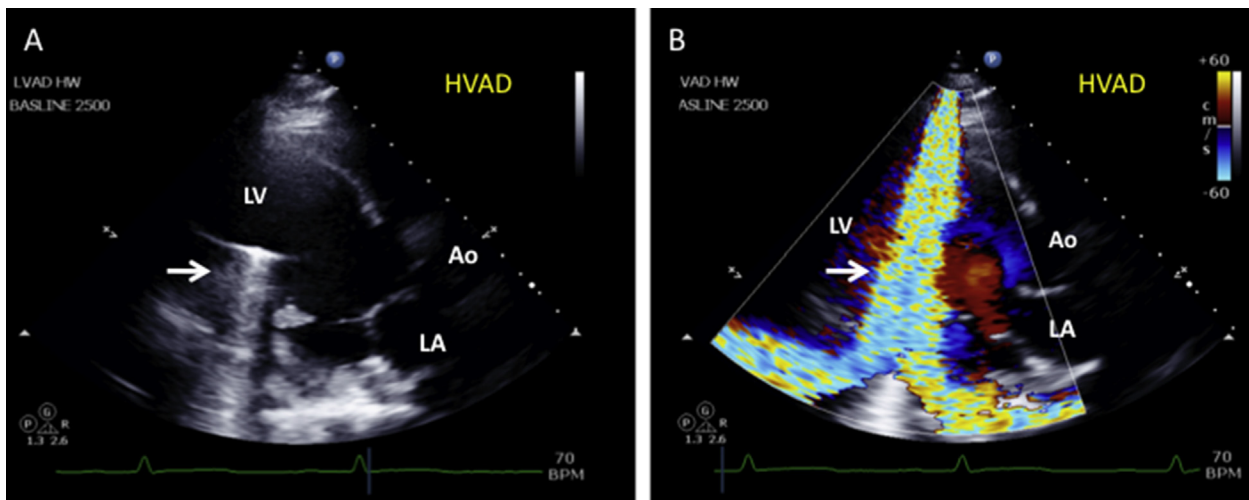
(A) HVAD inflow-cannula artifact (arrow), 2D parasternal long-axis view, as evaluated by TTE. (B) Typical color-flow Doppler artifact (arrow) associated with the HVAD inflow cannula. This artifact also prohibits spectral Doppler interrogation of the inflow cannula (as in [Figure 11B](#)). Inflow-cannula flow must be surmised by other means (eg, outflow-graft and RVOT flow, AV opening, and LV size changes during pump-speed changes). See also [Videos 29](#) and [30](#).
